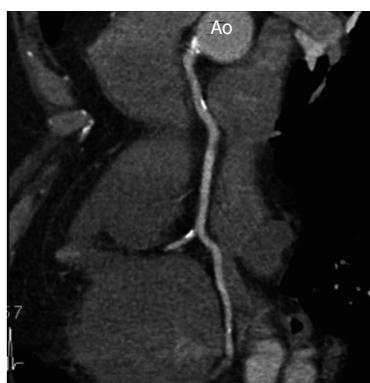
Transverse Multi-slice computed tomography scan in subtype (Lipton R-I) demonstrating the origin of the single coronary artery arising from the right sinus of Valsalva supplying the whole heart.
